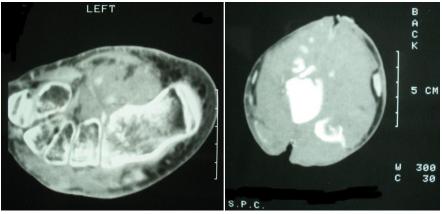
Axial CT of the left foot: heterogeneous osteolytictumor of tarsus and metatarsal with calcification and invasion of soft tissues.
